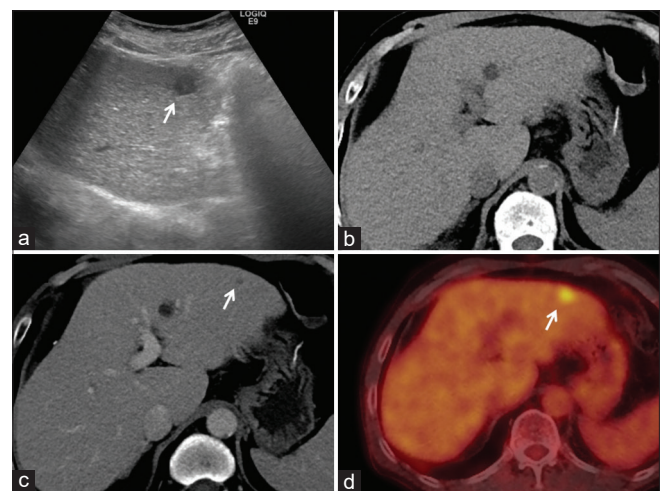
A 53-year-old woman affected by breast cancer. Detected with ultrasound (a), the lesions missed with noncontrast-enhanced computed tomography (b), contrast-enhanced computed tomography (c) (white arrows, 4 mm) at S3 of liver. The lesion showed fluorodeoxyglucose uptake on positron emission tomography-computed tomography scan (d)
